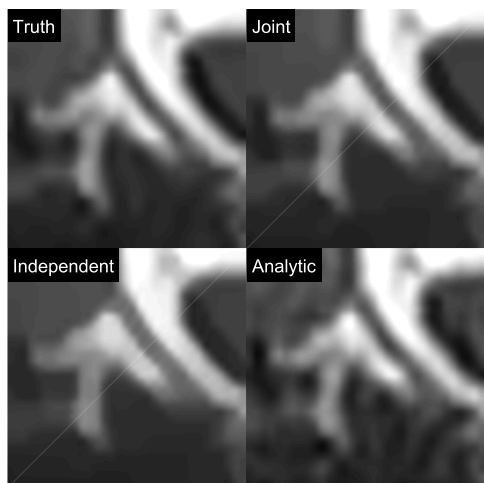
and Figure 10 display ROIs for CT and MRI images, respectively. CT ROIs focus on bony structures which absorb a large amount of X-ray photons, and therefore show much higher intensity. Similarly, MRI ROIs are chosen with tissues containing high density of protons, such as lipids, as they show stronger intensity in images. The evaluation of the images concentrates on the texture, artifacts, resolution and noise. By visual inspection, it is observed that the joint reconstruction (top right panel) in both CT and MRI provides better intensity and focus of texture on bone structure as compared with the independent and analytic reconstructions. It also achieves the best resolution among the tested reconstruction methods by comparison with the original image. In addition, the joint reconstruction also exhibits the best smoothness in background tissue, especially in MRI ROIs.
